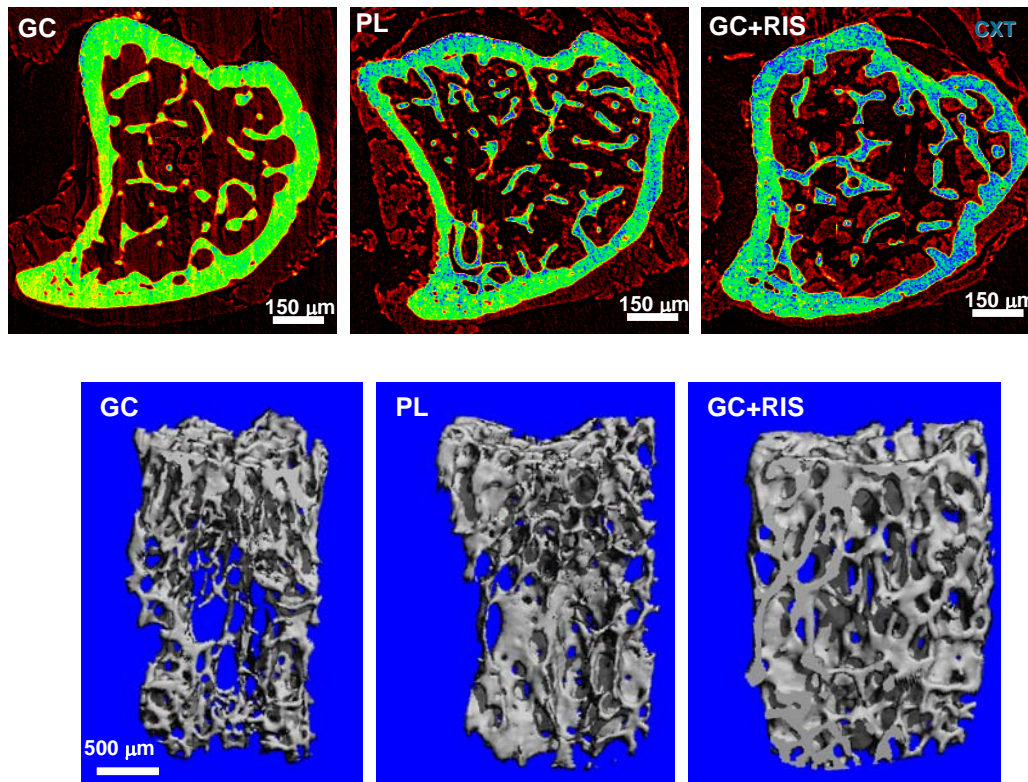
Computed x-ray tomography (XTM) of human trabecular bone showing the marked deterioration in the degree of bone mineralization following steroid (GC: glucocorticoid) treatments for 1 year, compared to regular (PL: placebo) bone, whereas concurrent treatment with bisphosphonates (RIS: Risedronate) recovers this loss in degree of bone mineralization. Such steroid treatments were found to degrade the fracture toughness of cortical bone by some 20%; however, when taken with bisphosphonates, the bone-matrix toughness increased by ~24%. Shown in the figure are (upper panel) representative XTM cross-sections and (lower panel) the distribution of 3-D degree of bone mineralization for human iliac crest biopsies treated with baseline (PL), GC+PL for 1 year, and GC+RIS treatment for 1 year. (after Balooch, Yao, Balooch, Nalla, Porter, Lane, and Ritchie, *Nature Medicine*, in review 2006).
